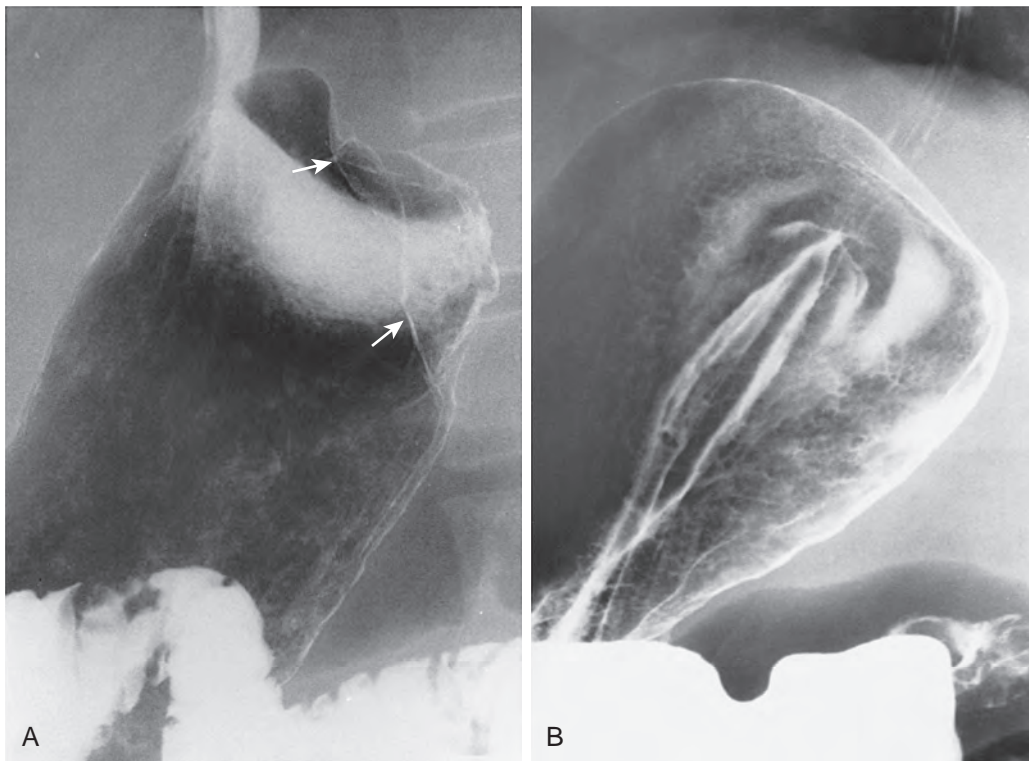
Inadequate gaseous distention mimicking a fundal tumor. A. Double-contrast radiograph of the stomach shows a possible infiltrating lesion (arrows) on the posterior wall of the fundus. B. After administration of additional effervescent agent, there is better distention of the fundus, eliminating the possibility of tumor. Note how the normal cardiac rosette is now visible.
